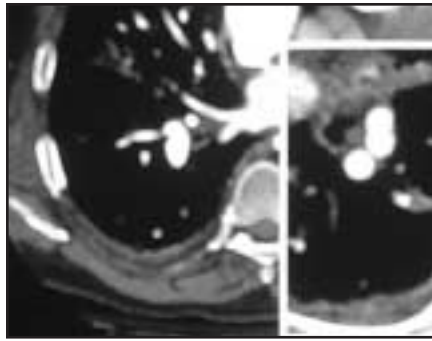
A and B. A small subsegmental pulmonary embolus well demonstrated by multislice CT. Coronal oblique reconstructions of the data show multiple small emboli in the peripheral pulmonary vasculature.
